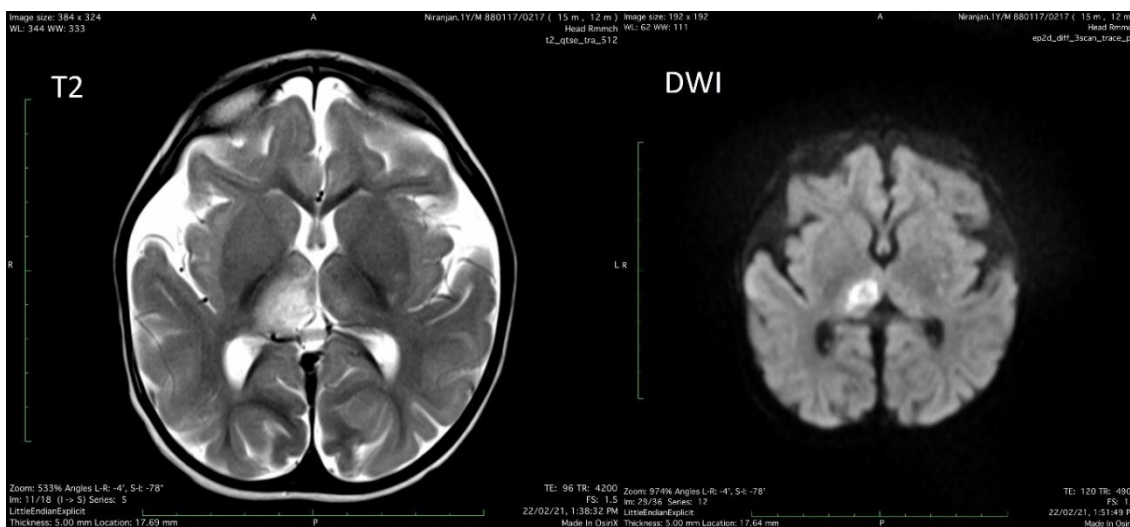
MRI depicting acute infarct in right thalamus
